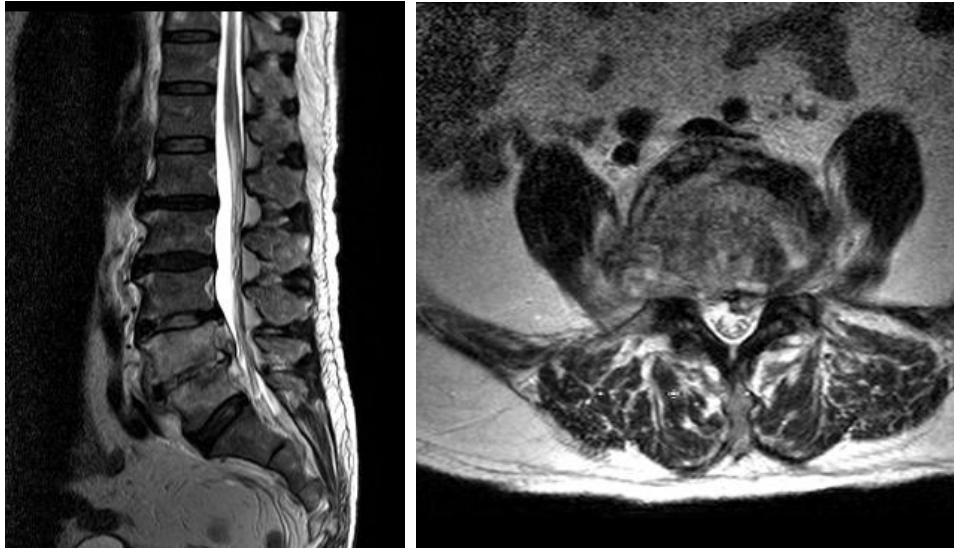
Lumbo-sacral MRI taken prior to commencing treatment showing infective spondylodiscitis features.
